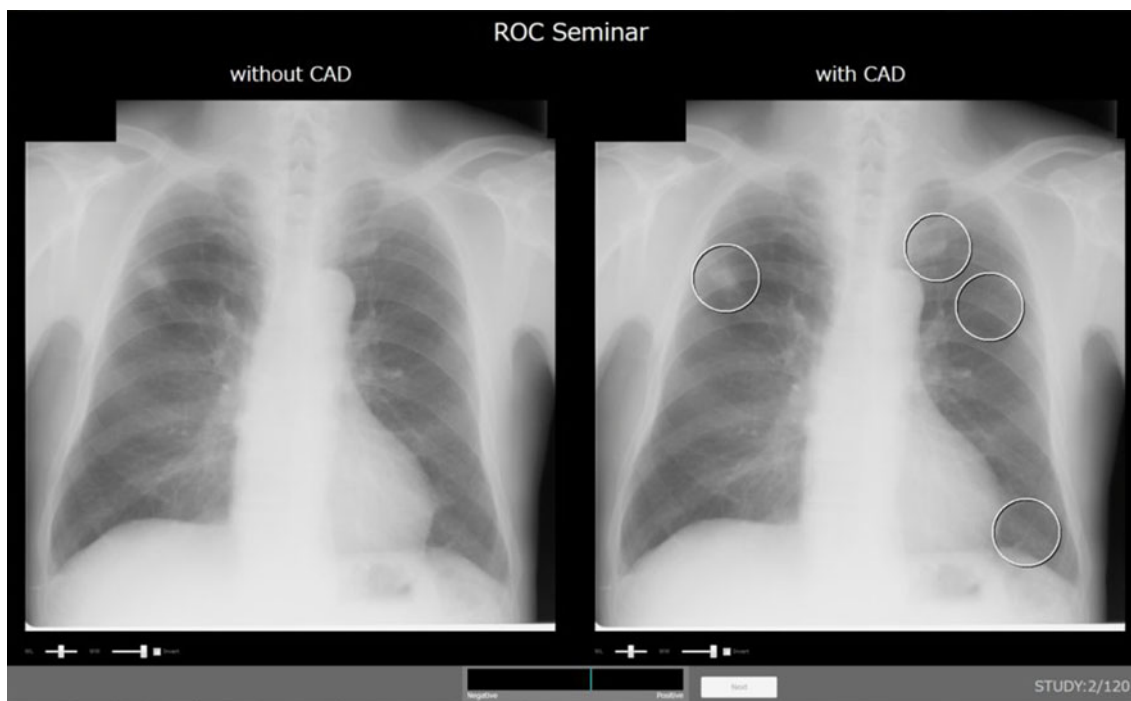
Screen shot of the computer interface for viewing two images in the ROC observer study. *Left window* displays an original chest radiograph, and the *right* displays that with CAD marks (*circle*) for
